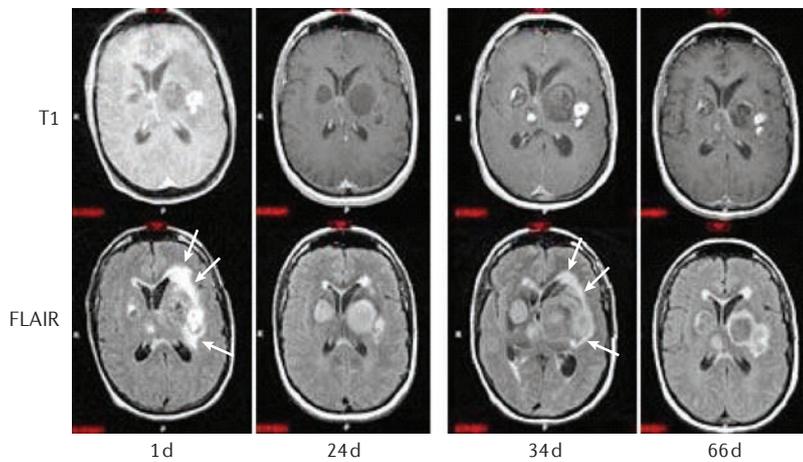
Corticosteroid treatment can reduce brain oedema in patients with HIV-negative cryptococcal meningitis. MRI scans demonstrate reduced brain oedema (arrows) after treatment with corticosteroids in an HIV-negative patient with CM and PIIRS. T1 and FLAIR weighted MRI scans of a patient with *Cryptococcus gattii* infection and autoantibody against granulocyte-macrophage colony stimulating factor treated with amphotericin B from day 1 to day 66, with adjunctive prednisone (50 mg daily) between day 1 and day 24. Corticosteroid therapy was stopped on day 24, but then re-instituted at days 34–66 after clinical deterioration. Reproduced from Panackal, A. A. *et al.* Paradoxical immune responses in non-HIV cryptococcal meningitis. *PLoS Pathog.* 11, e10047884 (2015); used under CC BY: <http://creativecommons.org/licenses/by/2.0/legalcode>.
